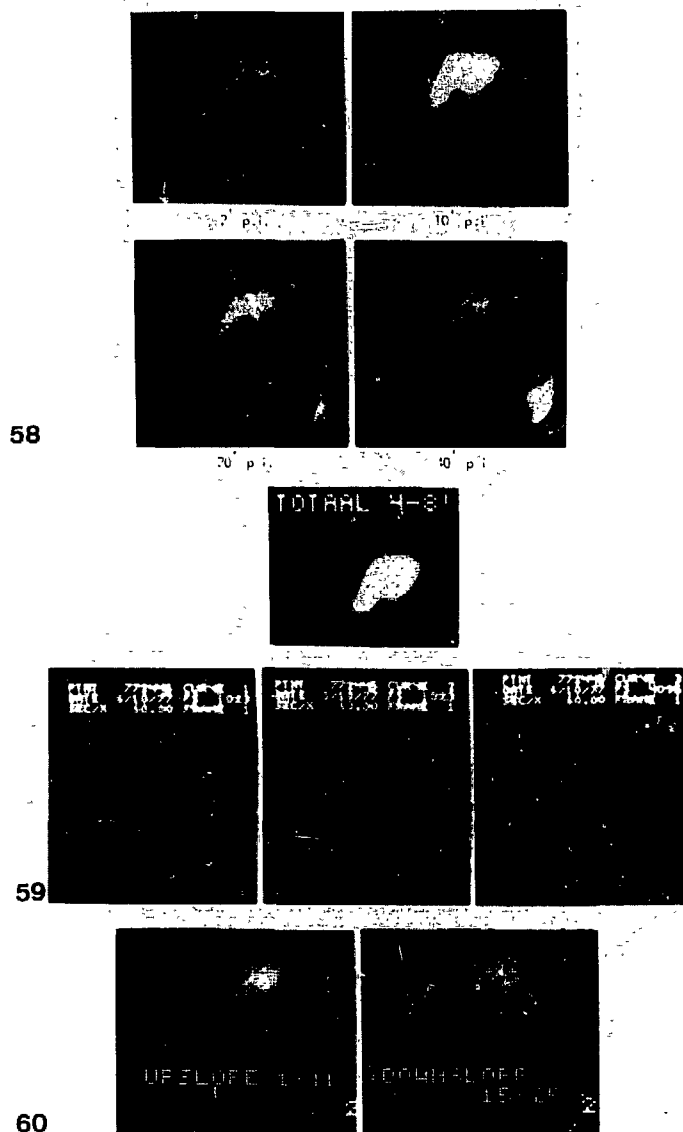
58-60 Cholescintigraphy in a patient with liver cell carcinoma.
